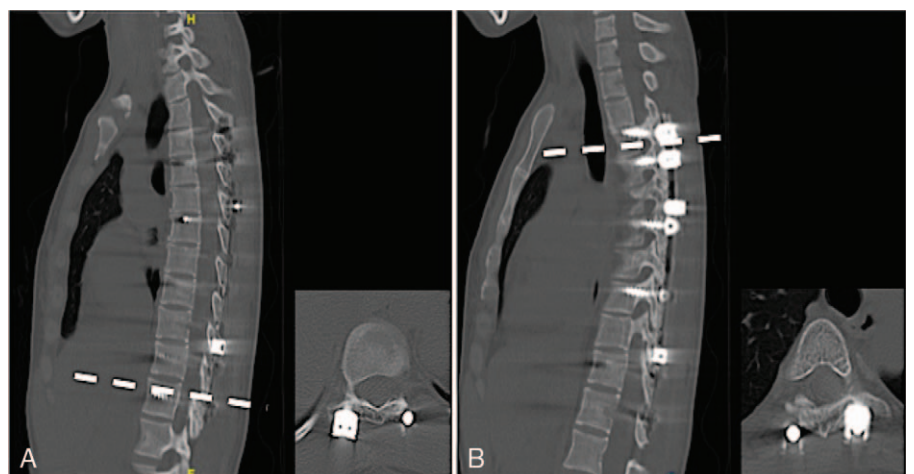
CT scans at 4 1/2 months postoperation showing fusion at the proximal and distal anchor site. CT indicates computed tomography.
